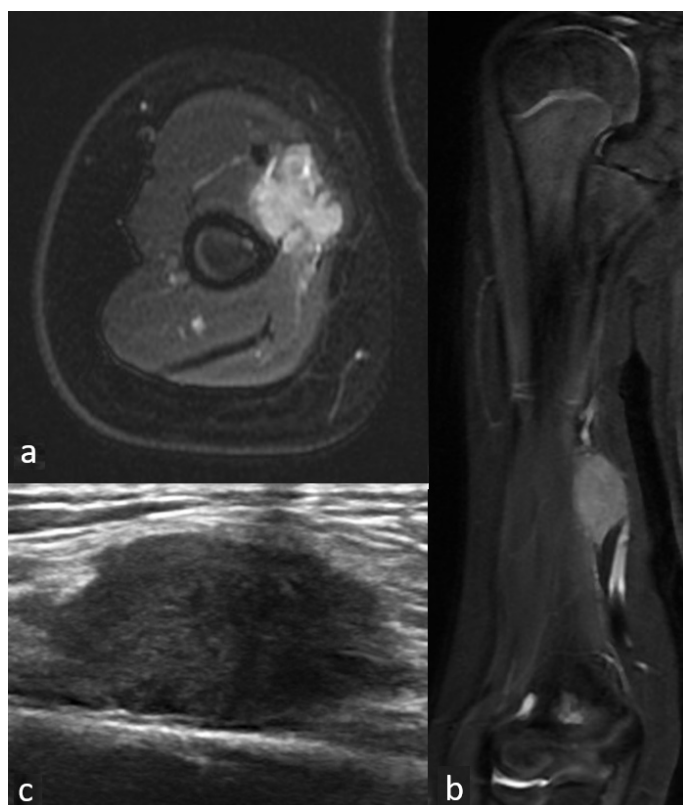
Magnetic resonance images of case 1. (a) axial fat-saturated T2-weighted image and (b) coronal STIR sequences show an ovoid-shaped hyperintense lesion with lobulated margins in the middle part of the right arm. Ultrasonography of case 2 (c): a well-delineated hypoechoic nodule appeared in the subcutaneous tissue.
